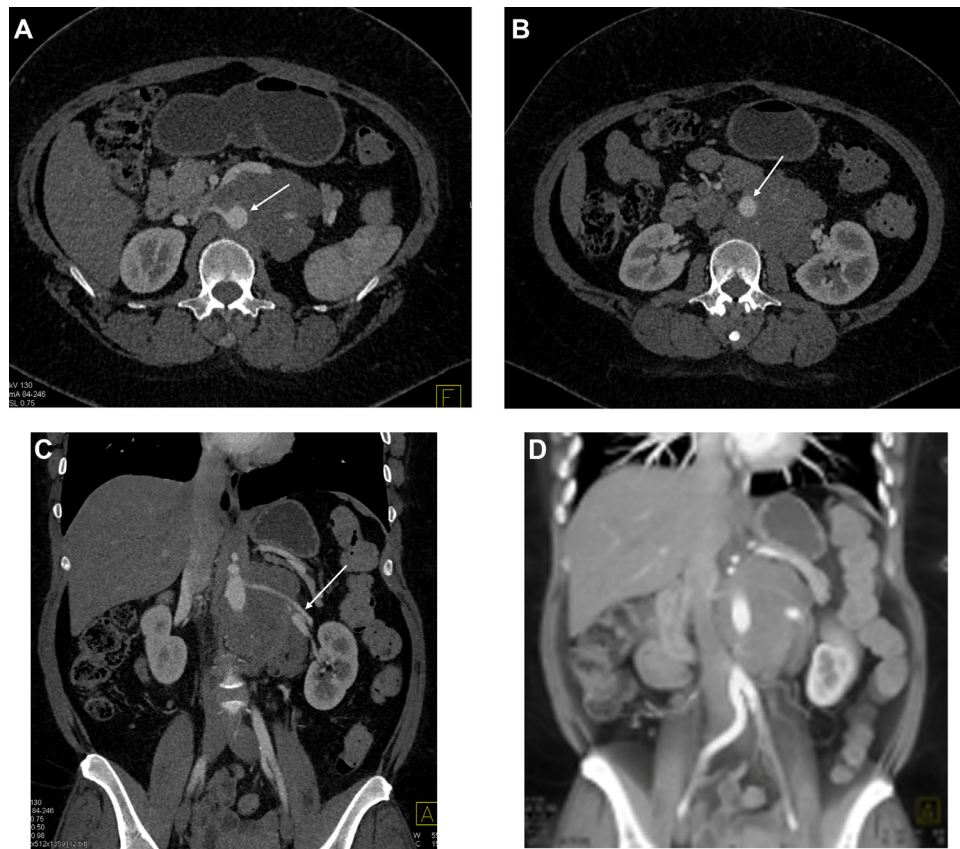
49-year-old female with symptoms of nausea, vomiting, abdominal pain, and fullness. (A-B) Axial contrast-enhanced CT scans demonstrate a 11.7 x 8.3 x 6.4 cm low attenuation mass (30 HU) encasing the aorta (arrow) and renal arteries. No evidence of bone involvement is seen. (C) Coronal CT scans demonstrate the displacement of the left kidney and the vascular encasement including the left renal artery (arrow). (D) 3D mapping with volume rendering defines the extent of the tumor and the lower density nature of the mass.
